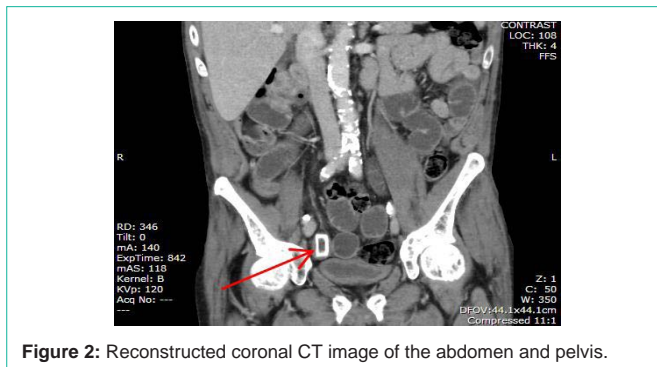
Reconstructed coronal CT image of the abdomen and pelvis.
